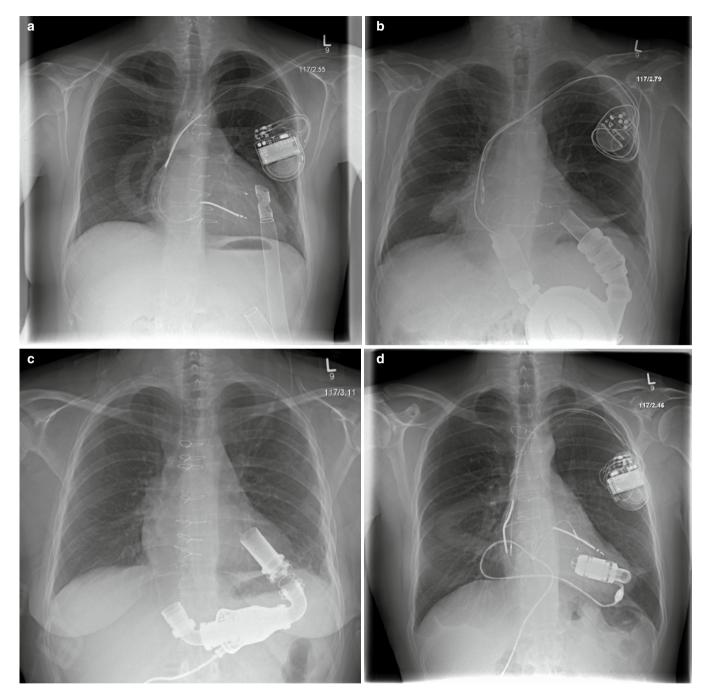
Chest radiographs of patients receiving LVAD support. In each case the inflow is connected to the apex of the left ventricle and the outflow graft to the ascending aorta. Note that second-generation axial impeller devices (\mathbf{c} and \mathbf{d}) are much smaller than the first-generation devices. (a) Thoratec Pneumatic (paracorporeal) (b) HeartMate I (c) HeartMate II (d) Jarvik.
